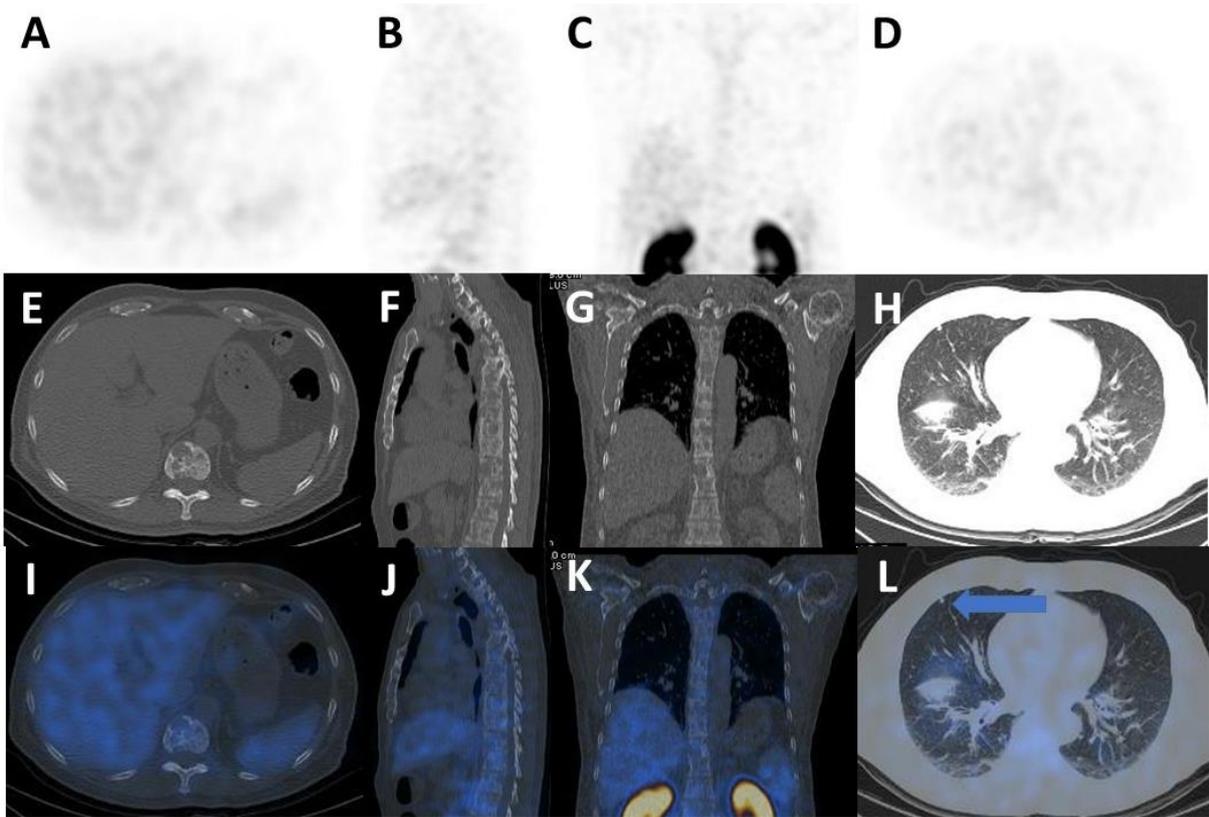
(A-L) SPECT, CT and fused SPECTCT images in axial, sagittal and coronal view from bone metastases as well as in axial view from lung metastasis
